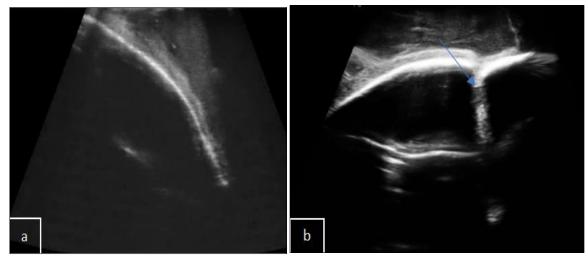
Ultrasound images of the frontal region in coronal (a) and axial (b) plans, showing a well-defined hypoechoic lesion with areas of heterogeneous echogenicity, consistent with a complex cystic structure suggestive of a mucocele, with a petrous channel (blue arrow) connecting the mucocele to the intracranial
